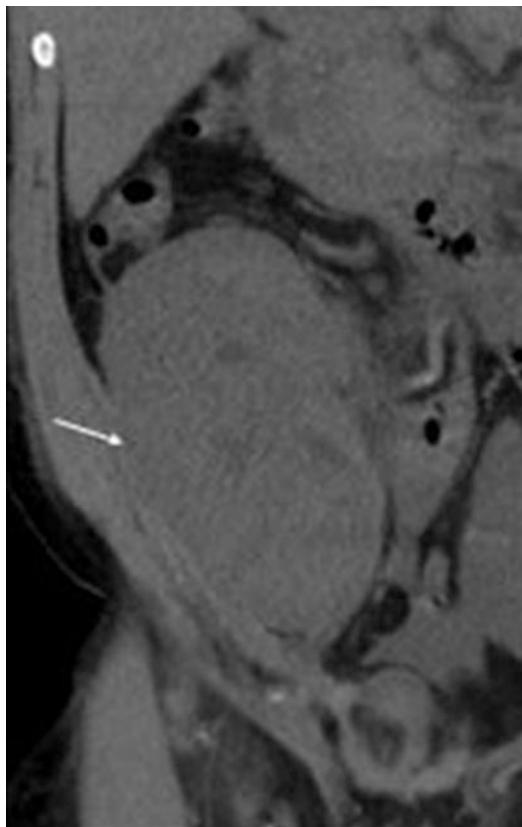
Enlarged organ size as an indicator of acute inflammation. Non-enhanced coronal CT image shows an enlarged right lower quadrant transplant kidney (arrow). Abnormal renal enlargement in this 36-year-old man was due to acute transplant rejection
